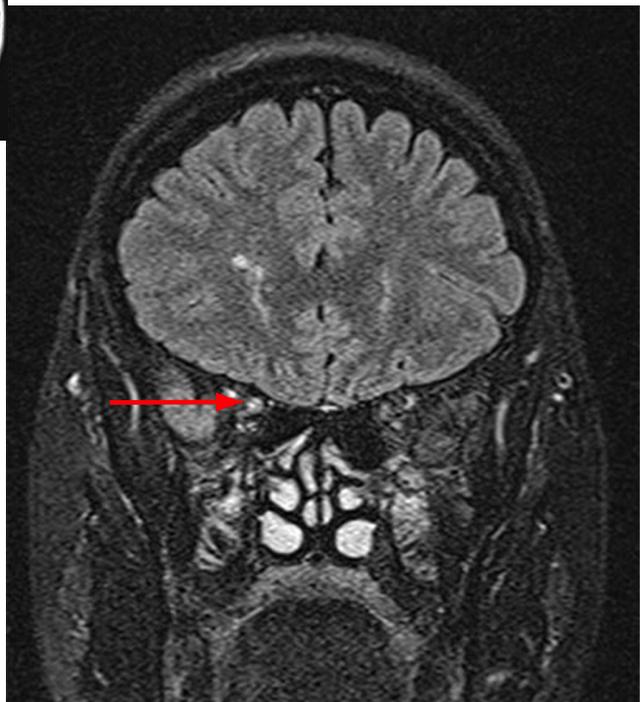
Coronal T2 - FLAIR sequence showing enhancement of the right optic nerve (arrow).
